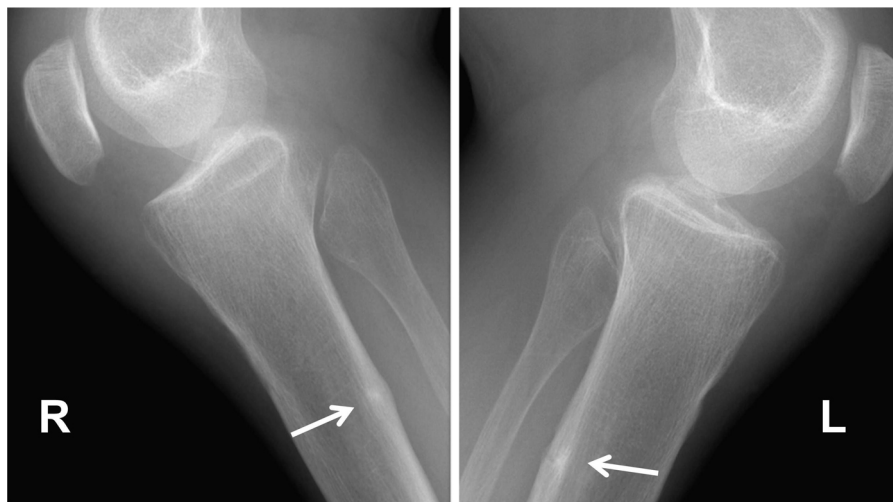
Lateral radiographs of right and left tibiae and fibulae showing symmetrical Looser zones with evidence of healing on the right.
